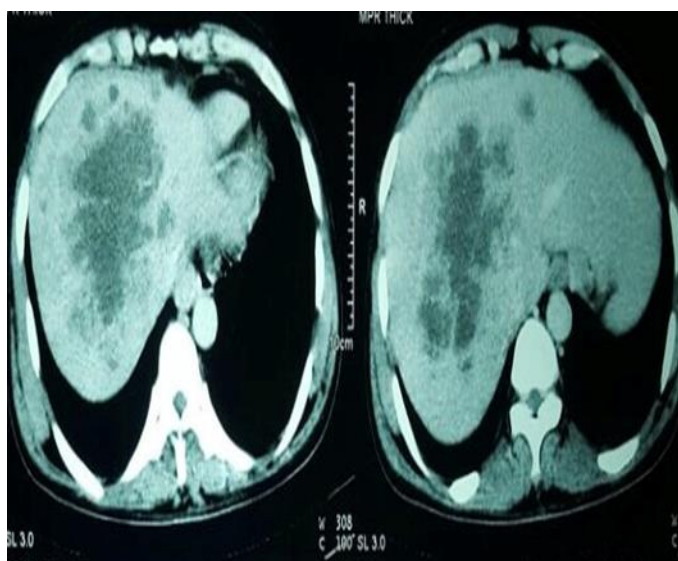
CT showing multiple liver abscess- Transverse cut
